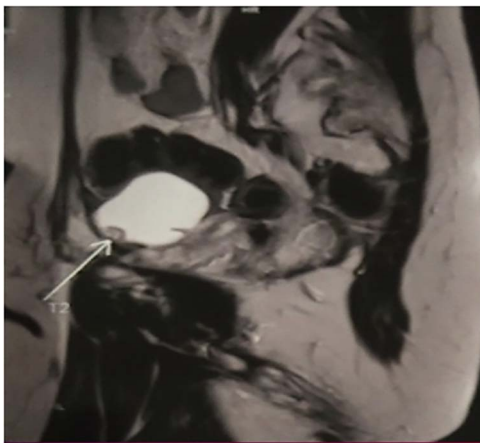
MRI image of the patient's pelvis sagittal T2-weighted image.
